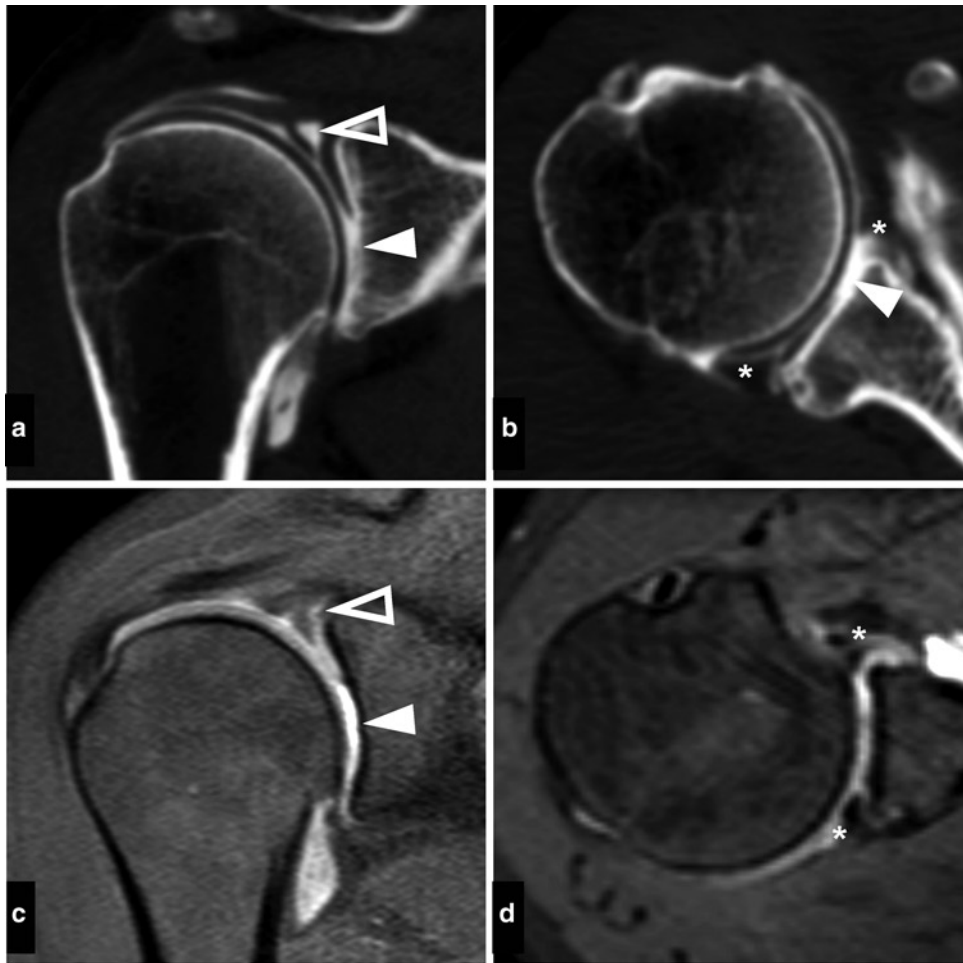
(a–d): (a, b) Computed tomographic (CT) arthrography of the shoulder in a 48-year-old woman shows a grade 4 cartilage lesion of the antero-inferior aspect of the glenoid cavity (*arrowhead*). (c, d) MR arthrography performed the same day shows the same
